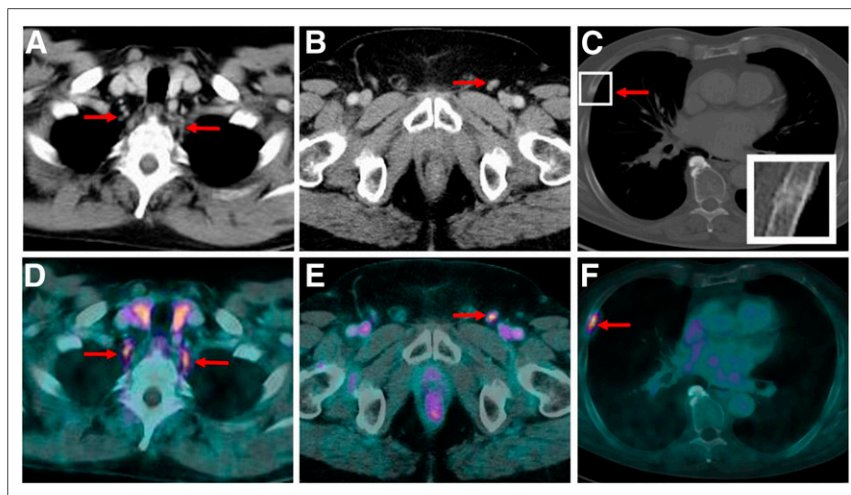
CT images (top) and ^{18}F -PSMA-1007 PET/CT images (bottom) of patient presenting with PSMA-ligand–positive, typically tear-drop–shaped cervical ganglia on both sides prevertebrally (A and D), unspecific PSMA-ligand uptake in nonenlarged left inguinal LN (B and E), and focal PSMA-ligand uptake in nondisplaced fracture of rib with corresponding fracture line and callus formation on CT images (C and F).
